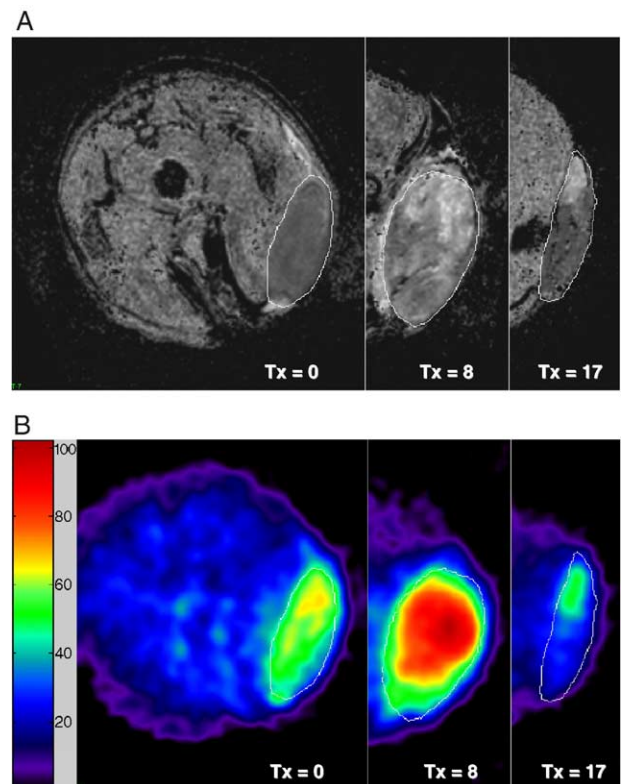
Quantitative proton ADC maps (A) and corresponding coregistered sodium MR images (B) of treated tumors on Days 0, 8 and 17 after a single dose of BCNU. Heterogeneous tumor ADC increases along with intensive sodium uptake can be seen on Day 8 posttreatment. On Day 17, tumor ADC values and sodium concentration are returning to their pretreatment values. Repopulation of the tumor mass can be seen on Day 17 as a gray (low diffusion) region of the tumor on the ADC map (A), which corresponds to the low Na concentration in the sodium image (B).
